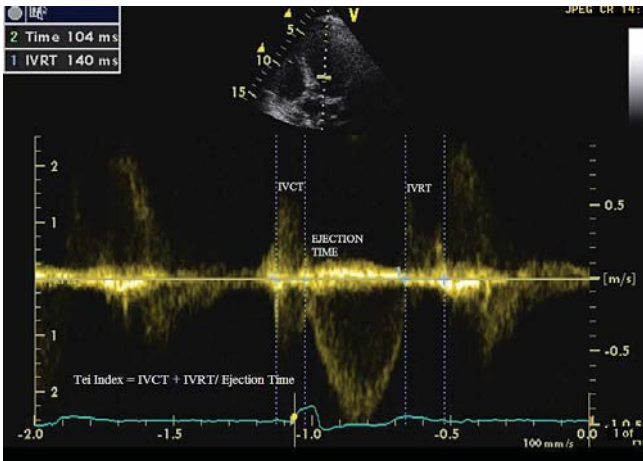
Tei index calculated as IVCT + IVRT/Ejection time use Doppler.
